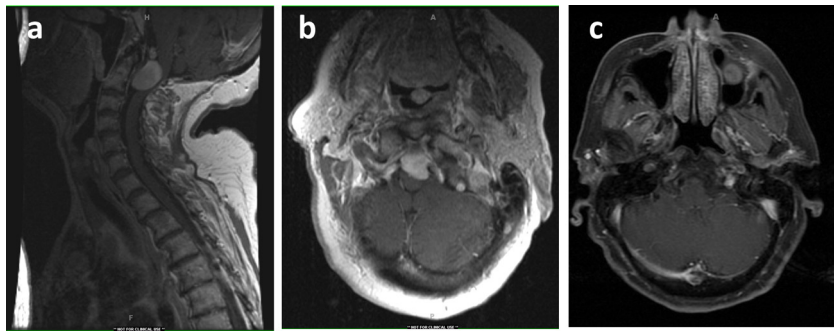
This 84-year-old female patient experienced a significant deterioration for her neurological condition several months pre-op and presented with neck pain, dysesthesias and was unable to walk properly. MRI scans (a–b) revealed a large spinocranial anterior meningeoma (2.3 cm × 1.3 cm × 1.5 cm) displacing neuroaxis posteriorly. She underwent a posterior suboccipital midline approach with C1 and C2 laminectomy. Post-operatively, she had a very good recovery, with headache and dysesthesias resolved and was able to walk normally. MRI (c) at follow-up showed complete excision of the tumor.
